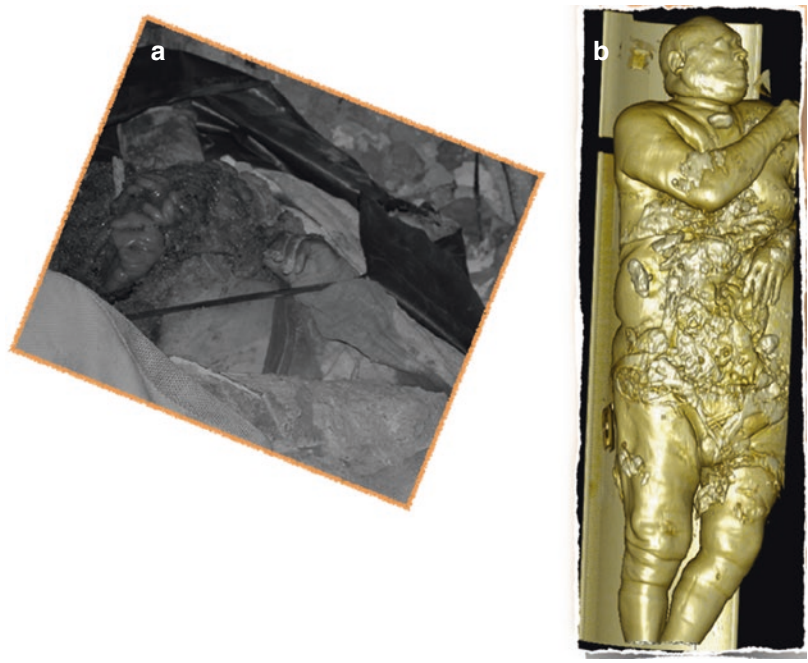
(a) Photography of an eviscerated corpse on recovery site in building collapse in Palermo (Italy), December 2012. (b) 3D VR reconstruction of the whole-body CT scan of the same body
